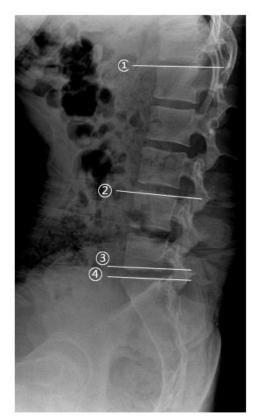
Radiograph measurements of the lumbosacral region. Lumbar lordosis angle (the angle between 1) and 4) lines), upper lumbar angle (between 1) and 2) lines), lower lumbar angle (between 2) and 4) lines), lumbosacral angle (between 3) and 4), and sacral slope angle (between 4) line and the horizontal plane)
